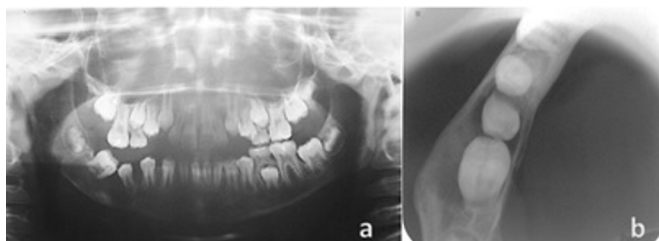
A) Orthopantomograph (OPG) showing a well-circumscribed radiolucent image measuring 5 x 2 cm in maximum dimensions, extending from the mandibular right parasymphysis to the mandibular right body and from alveolar crest to mandibular basis, involving roots of units 47 and 45 which are still not fully formed and causing deslocation of these teeth. B) Occlusal radiography showing cortical expansion due to lesion growth, but with no evidence of fenestrations.
